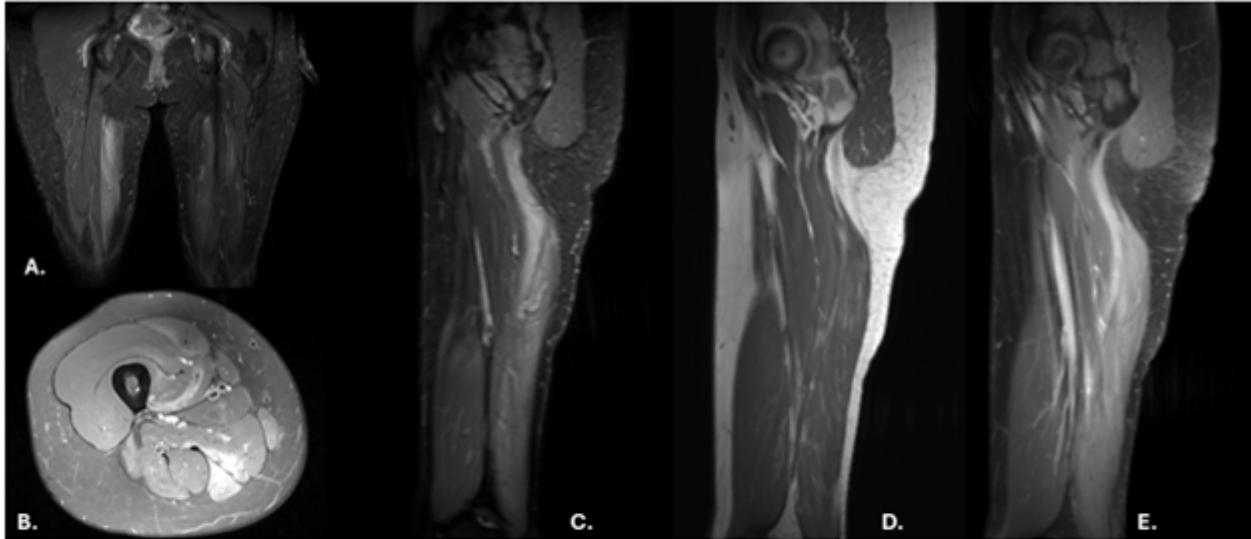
MRI thigh showing increased signal intensity and contrast enhancement most prominent in the adductor magnus and adductor longus. A. Coronal short tau inversion recovery (STIR). B. Axial intermediated-weighted fat-suppressed turbo spin echo (TSE). C. Sagittal STIR TSE. D. Sagittal T1-weighted Pre-contrast. E. Sagittal T1-weighted Post-contrast.
